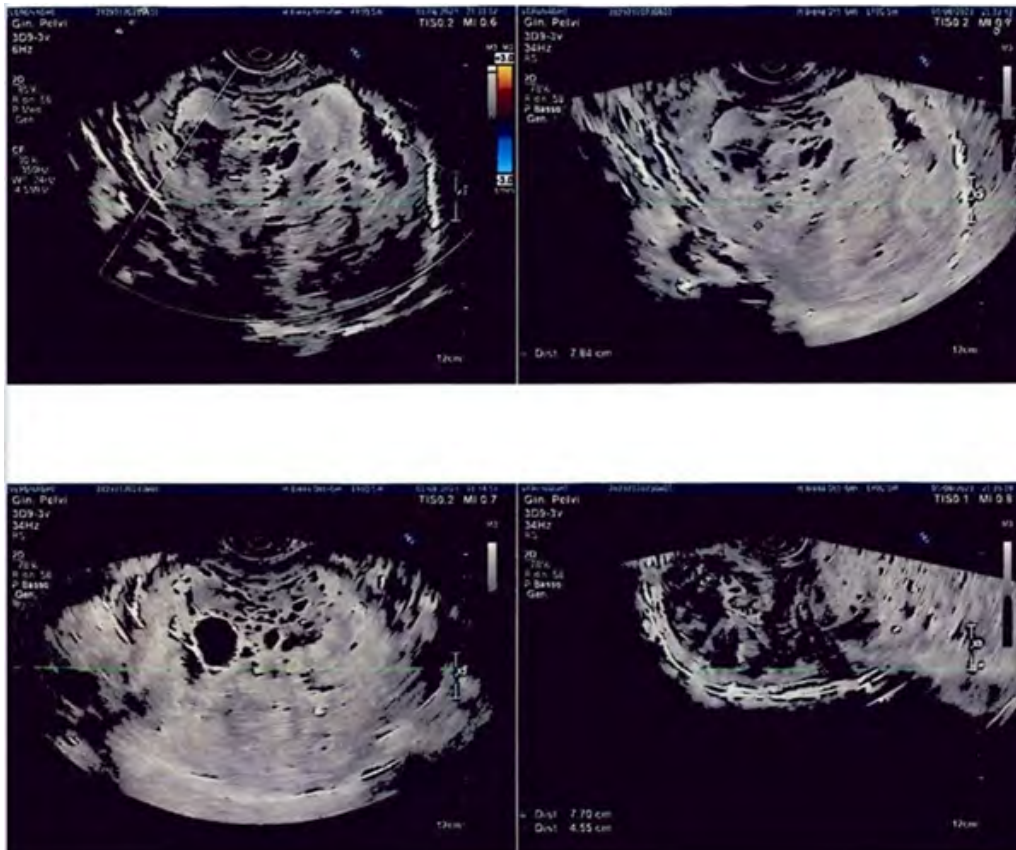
Transvaginal ultrasound showing thickened endometrial material with snowstorm pattern.
